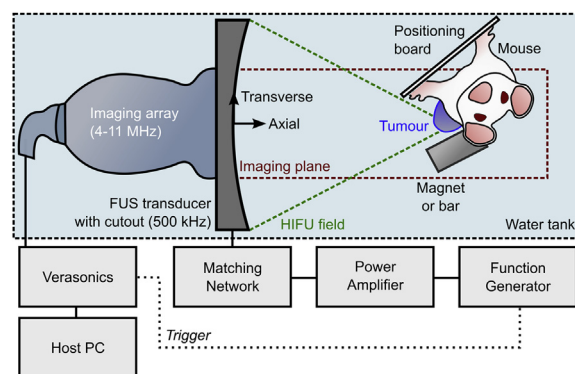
Overview of the setup for *in vivo* experiments (plan view, not to scale). Tumours were aligned with the focus of a 500-kHz focused ultrasound (FUS) transducer with a rectangular cut-out for a 4- to 11-MHz imaging array. B-Mode imaging was interspersed with passive acoustic recording of the emissions from cavitation during FUS transducer pulses. Transverse and axial directions are defined relative to the centre of the front face of the imaging array. Exposures were performed in the presence of a magnet or non-magnetic bar.
